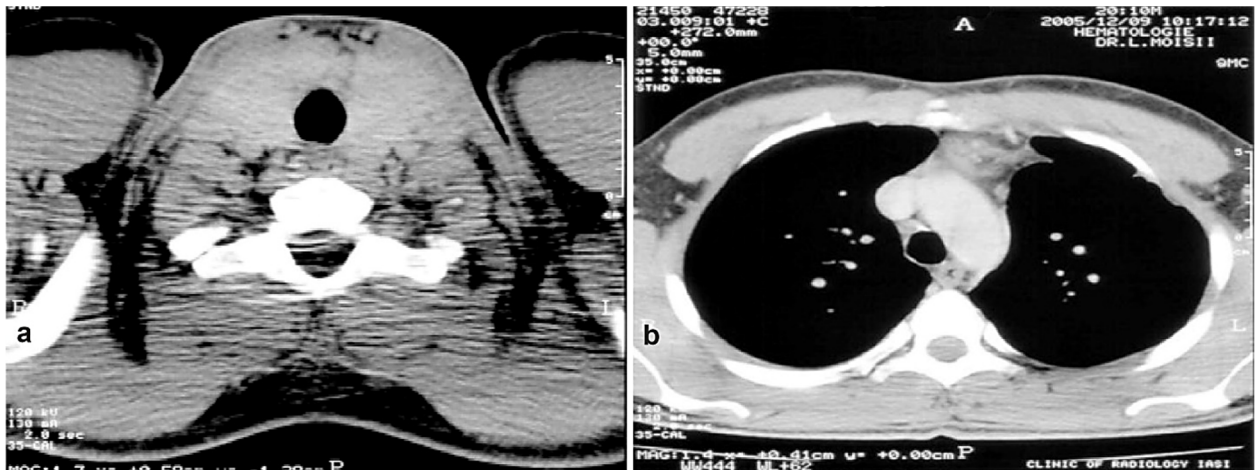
Case No. 4. M, 19-year-old. Thymic atrophy with gland degeneration of Hassall's corpuscles: (a) CT scan of the neck demonstrated a heterogeneously enlarged thyroid gland (axial view); (b) Thoracic CT scan revealed a nodular mediastinal mass suggestive for thymoma (axial view). CT: Computed tomography; M: Male.
